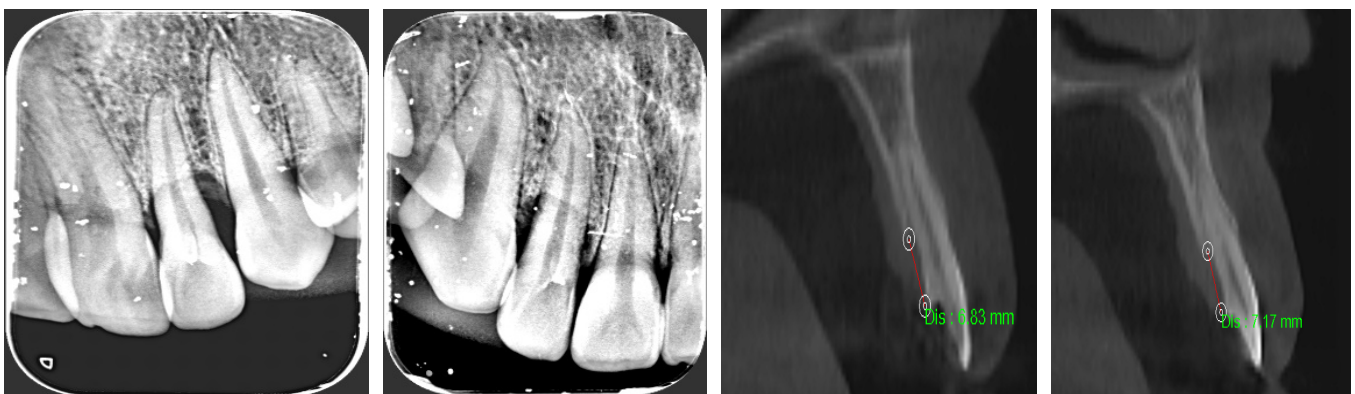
Preoperative periapical radiograph and cone-beam computed tomography
